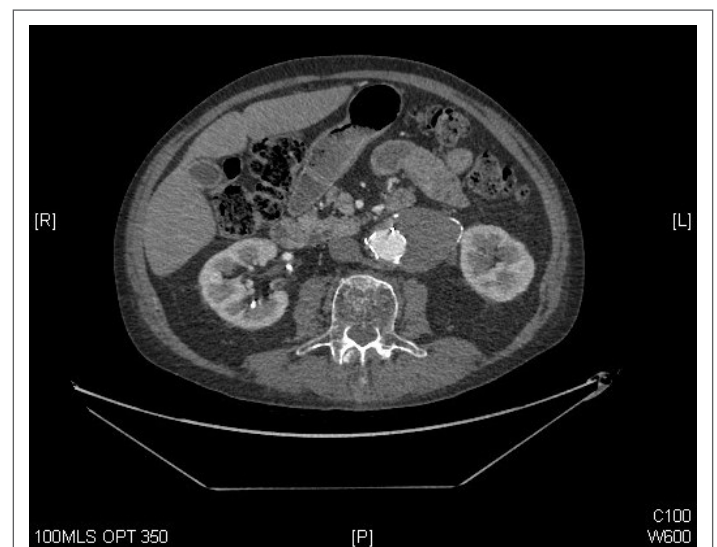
CT abdomen showing contrast within the aorta, the presence of the EVAR stent and the thrombosed aneurysm sac.
